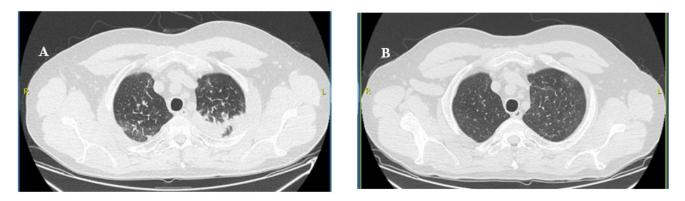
CT scan before corticosteroid therapy (A). CT scan one week after commencement of corticosteroid treatment (B)
